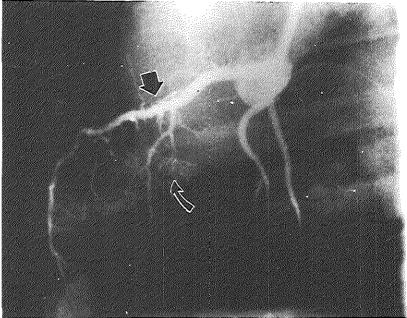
Top panel: Nominal 3.0-mm-diameter Wiktor stent placed 4 weeks previous in left anterior descending coronary artery (large arrow) and nominal 3.5-mm-diameter Wiktor stent placed in right coronary artery (small arrow) clearly visible during radiography. Bottom panel: Coronary angiogram in left inferior oblique projection showing patent left anterior descending coronary artery without intraluminal defects associated with stent (large arrow).
